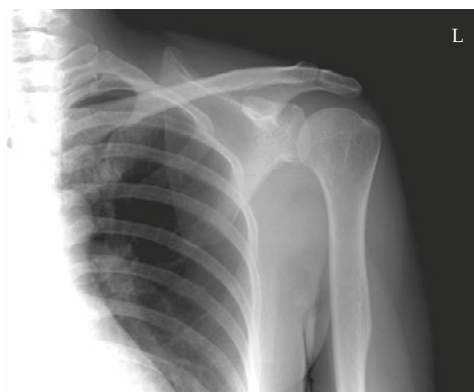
X-ray shows no calcium shadows at the 3-week follow-up of case 1.
